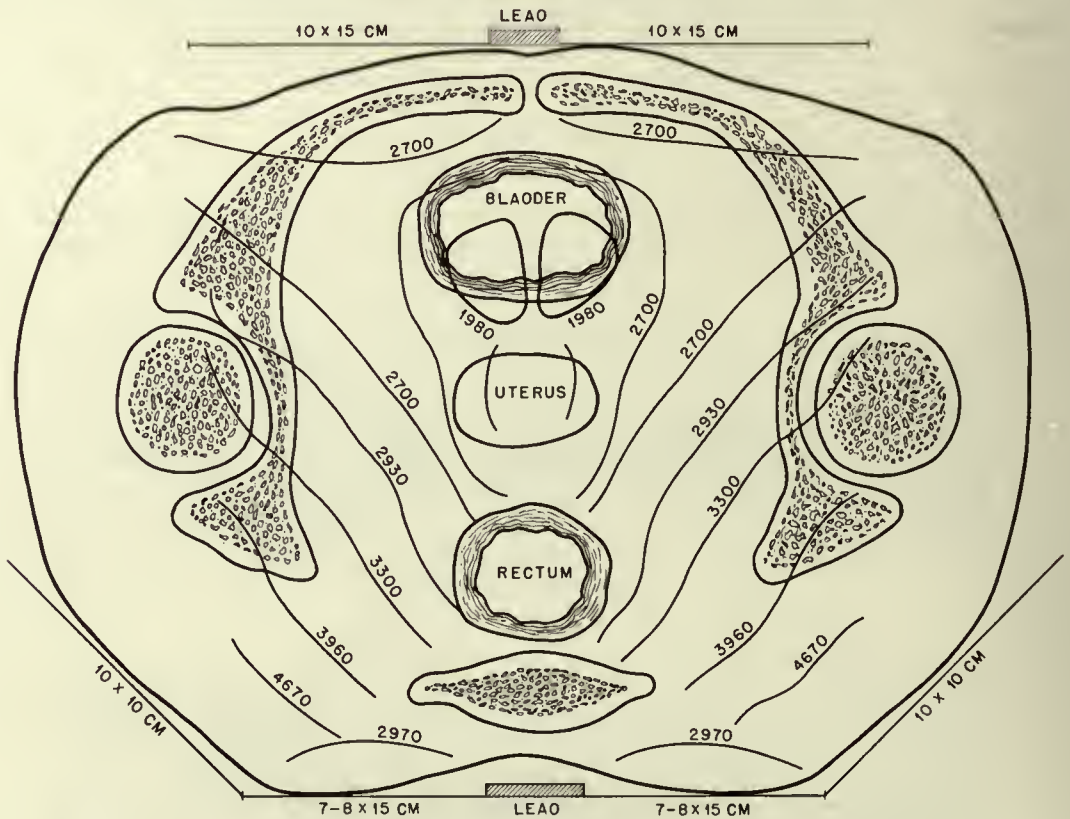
Isodose levels in roentgens (six fields; 220 kv; 5 ma; Thor I added filtrations; HVL, 1.35 mm of copper; 50 cm TSD; 25 r/min/amp).
